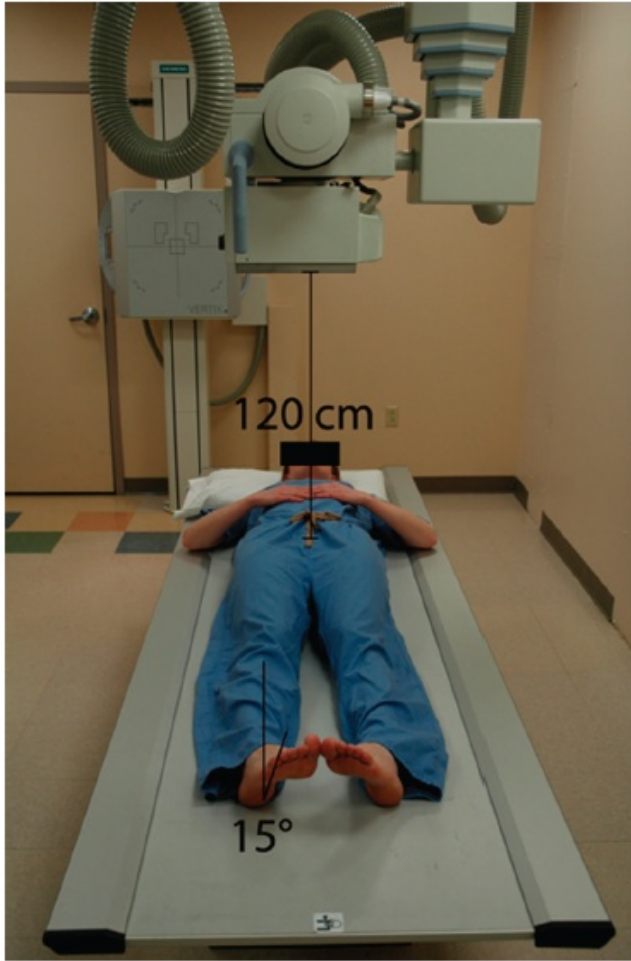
The positioning for an anteroposterior pelvic radiograph (taken from Clohisyet *al.*, 2008)
